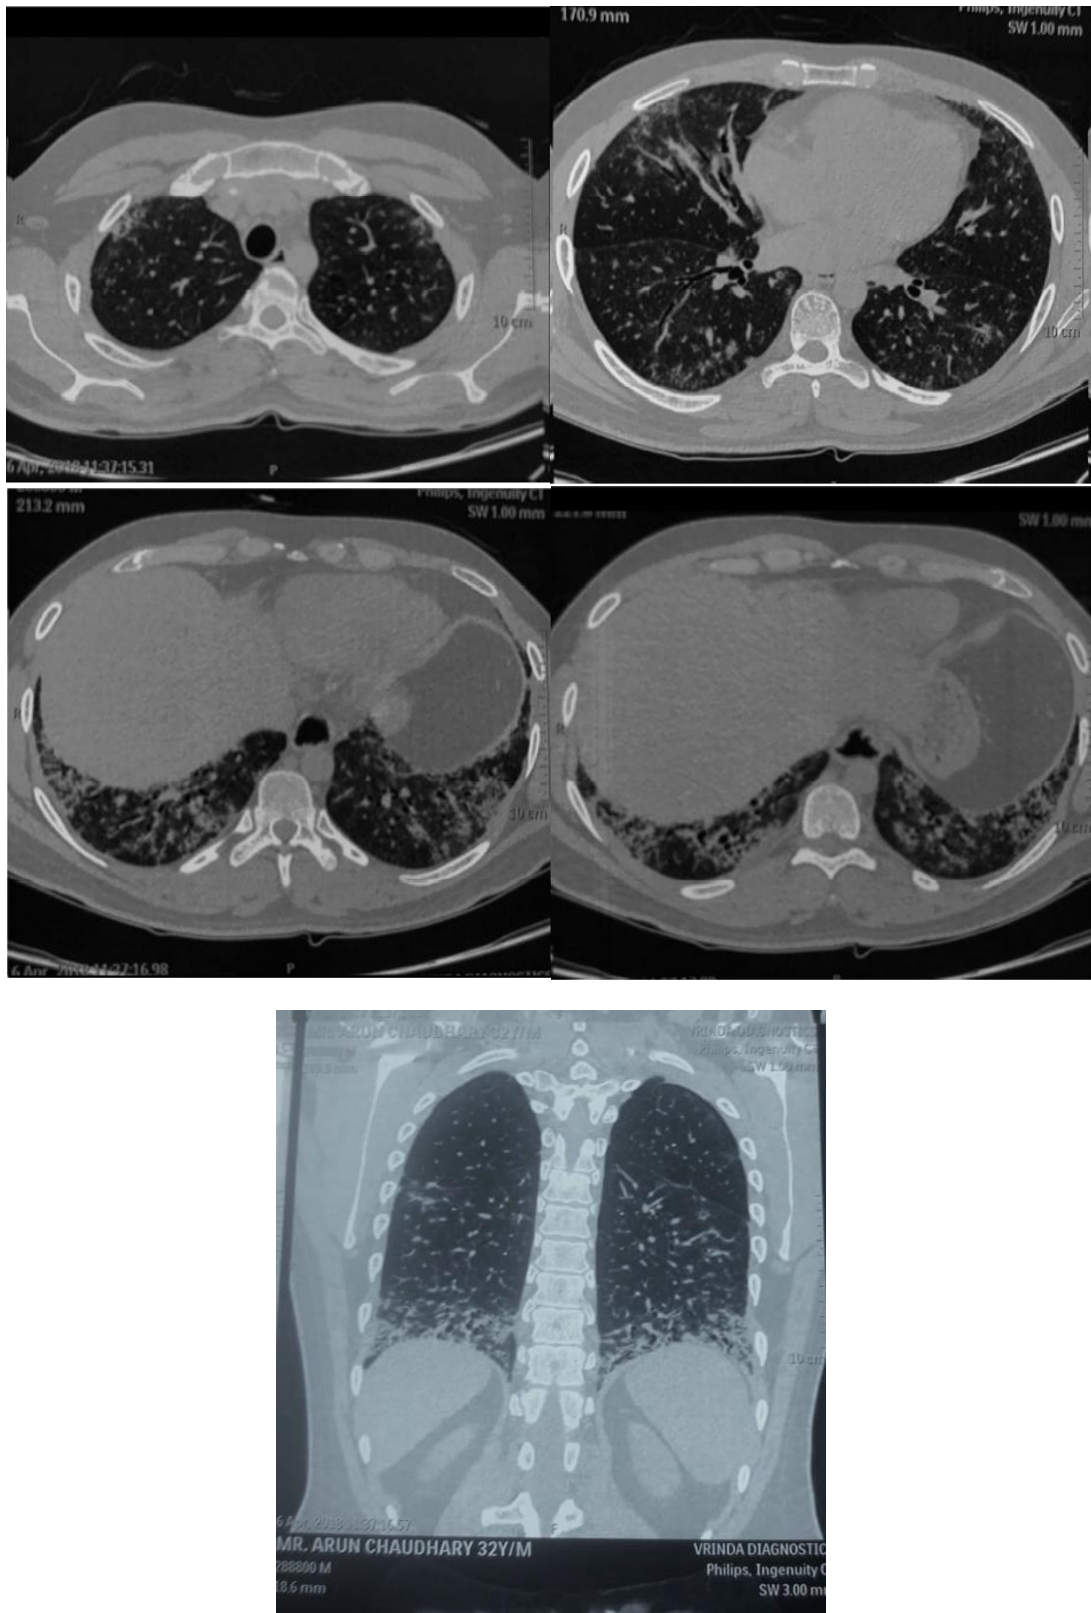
High-resolution CT scan (lung window) shows thickened intralobular and interlobular lines, hazy patches of increased attenuation, bilateral curvilinear bands of subpleural reticular hyper-attenuating areas, bilateral small cysts, traction bronchiectasis and areas of ground-glass attenuation.
